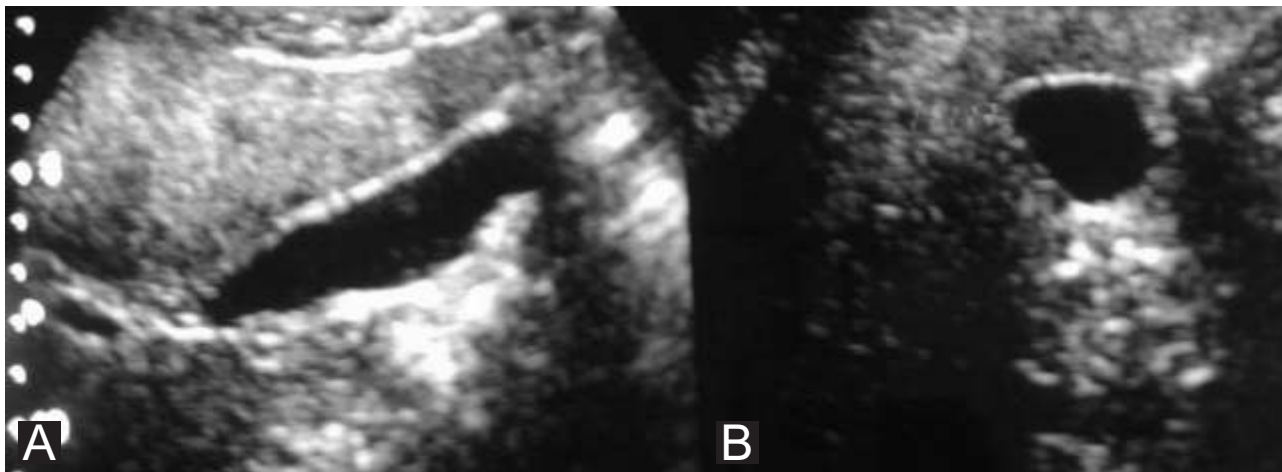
Ultrasonographic Gallbladder Image (A) Longitudinal Section and (B) Transverse Section
